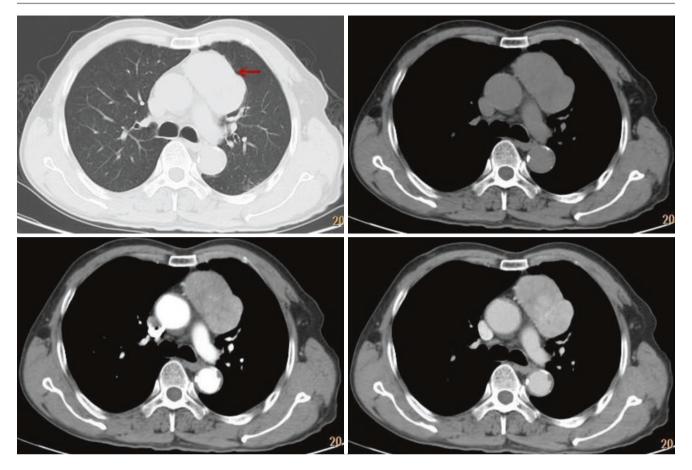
Chest CT images of a 72-year-old man complained of left ptosis, diplopia, and chest tightness for 1 month
